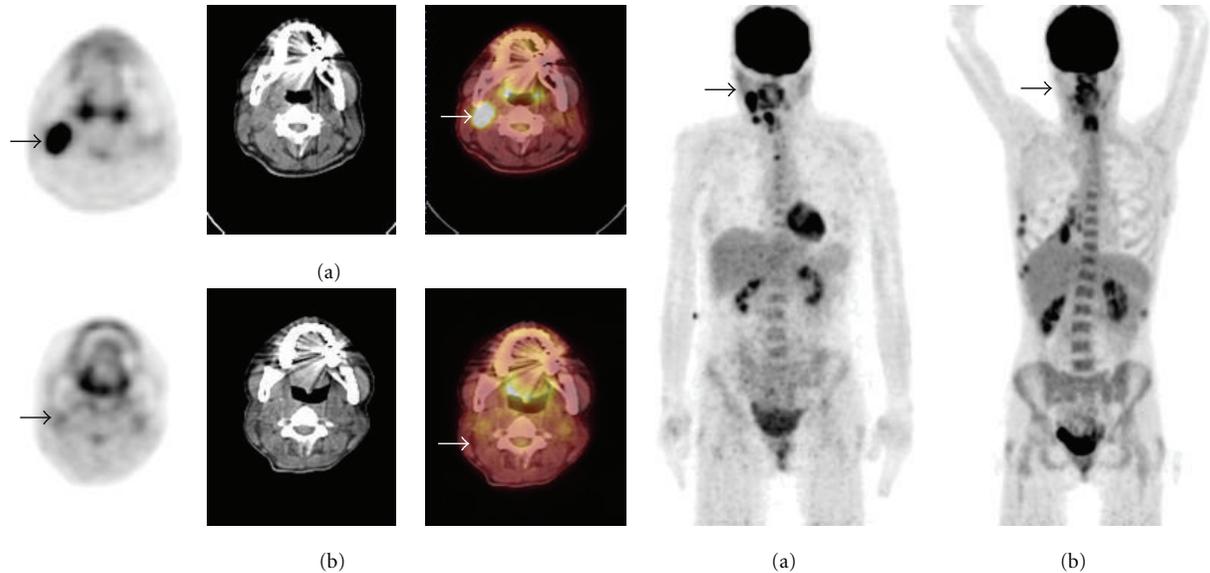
40-year-old woman with right side larynx squamous cell carcinoma and a right side cervical lymph node metastases underwent PET/CT imaging before and 1 month after completion of chemoradiotherapy. (a) Pretherapy axial PET, CT, PET/CT, and MIP images reveal intense FDG uptake in the right cervical lymph node (arrows). (b) After treatment axial PET, CT, PET/CT, and MIP images reveal decrease FDG uptake in the corresponding locations (arrows). Appearance was consistent with early response to chemoradiotherapy. FDG PET/CT was valuable in monitoring early response to treatment.
